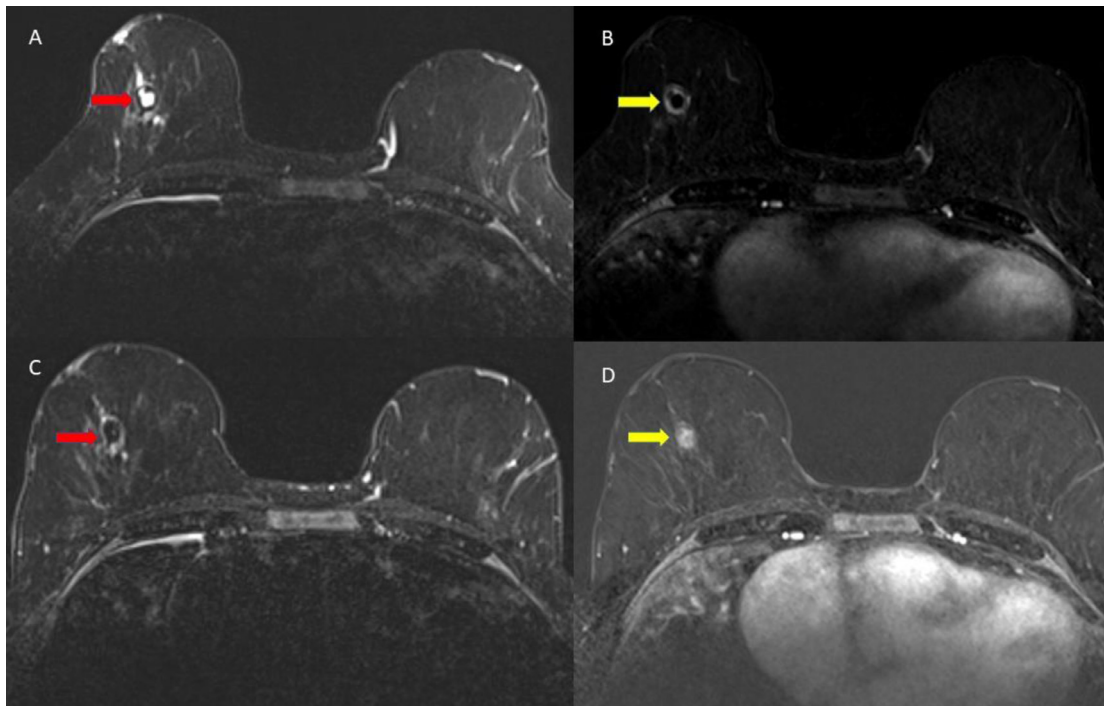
Magnetic resonance imaging (MRI) of the breasts from 6 months prior (A and B) and current exam (C and D). Axial T2 weighted fat saturated image (A) from 6 months ago demonstrated a T2 hyperintense cyst (red arrow) which demonstrates uniform rim enhancement (yellow arrow) on the axial postcontrast subtraction image (B). Axial T2 image from the current MRI exam (C) demonstrates loss of central T2 signal (red arrow), suggesting loss of prior cystic/fluid content. Heterogeneous enhancement of the mass (yellow arrow) in the axial post contrast subtraction image (D) suggests a solid mass rather than a benign cyst, considered a suspicious finding.
